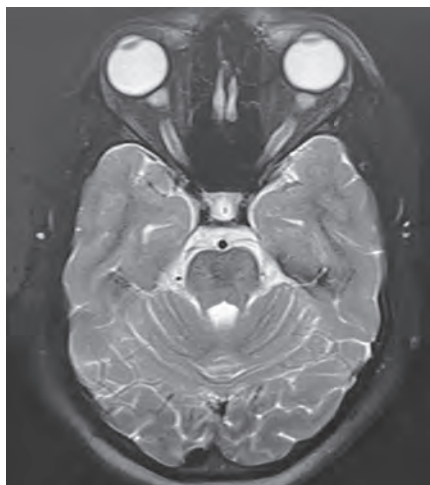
Magnetic resonance imaging (MRI) brain axial T2 image showing tortuous optic nerves, prominent perioptic CSF spaces with flattening of the posterior globe
